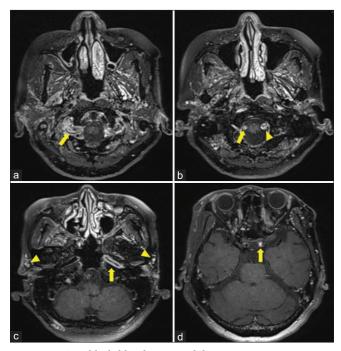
T1 black-blood post-gadolinium imaging sequence magnetic resonance imaging. (a) Vessel wall enhancement (VWE) of the V4 portion of the right vertebral artery (VA) was observed (arrow). (b) More distally, the right VA was occluded (arrow), and the VWE of the V4 portion of the left VA was observed (triangle). (c) VWE was observed in the petrous portion of the left internal carotid artery (ICA) (arrow), and VWE was also observed in the left and right superficial temporal artery (triangle). (d) Occlusion was observed in the supraclinoid portion of the left ICA (arrow).
